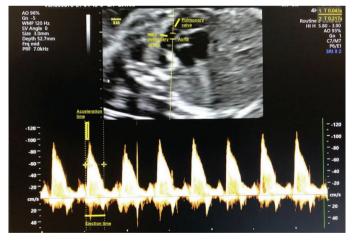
Fetal main pulmonary artery Doppler flow-trace
